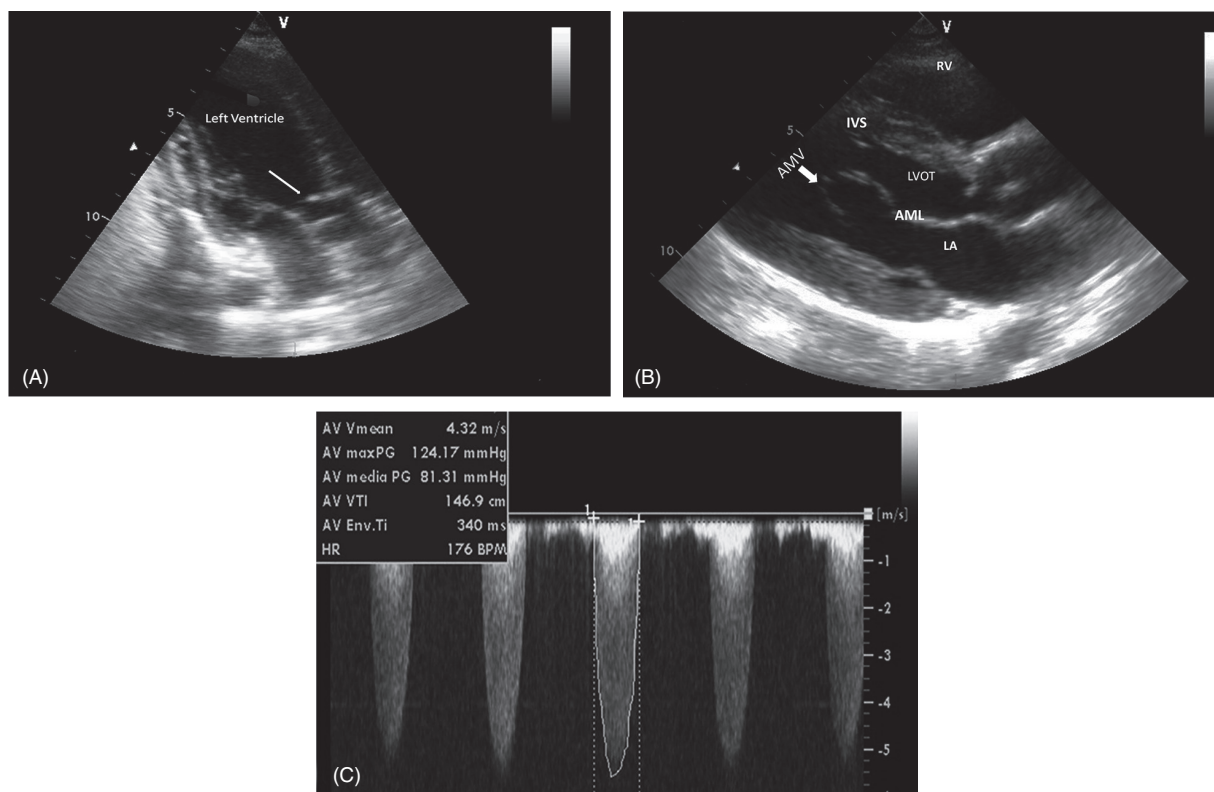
(A) Transthoracic echocardiography, 3-chamber apical view. The arrow indicates accessory mitral valve (AMV) tissue protruding into the left ventricular outflow tract (LVOT). (B) Transthoracic echocardiography, parasternal long-axis view: the AMV tissue is visualized as a spherical structure attached to the ventricular surface of the anterior mitral valve leaflet. (C) Continuous-wave Doppler echocardiographic examination showing the presence of high pressure gradient (peak, 124 mmHg; mean gradient 81 mmHg) between left ventricle and aorta. RV: Right Ventricle; IVS: Interventricular Septum; LA: left atrium; AML: Anterior Mitral Leaflet; LVOT: left ventricular outflow tract.
